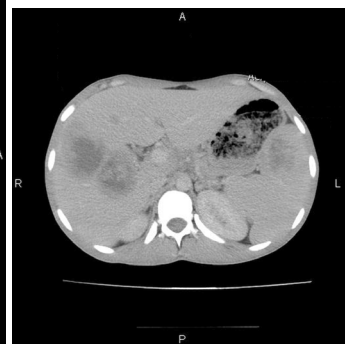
Abdomen CT+C – transversal scan plan. Heterogeneous nodular liver images with hypodense center and peripheral low enhancement.
